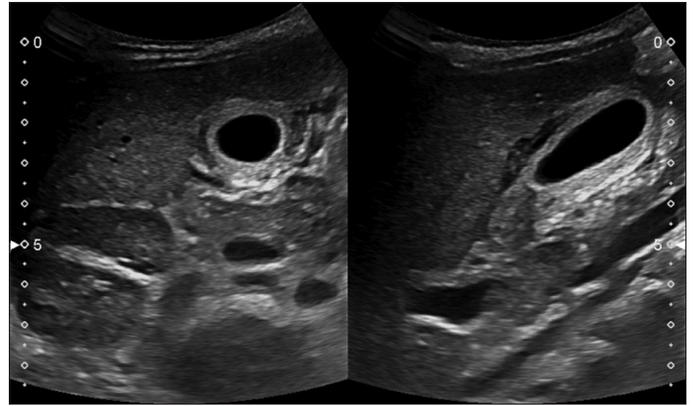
Ultrasound abdomen. Transverse and longitudinal sections using a curvilinear transducer reveal significant echogenic gallbladder wall thickness, especially in the body and fundus regions, along with hypoechoic pericholecystic edematous changes near the neck and proximal gallbladder body. No shadowing of gall bladder calculus or echogenic sludge was noted.
